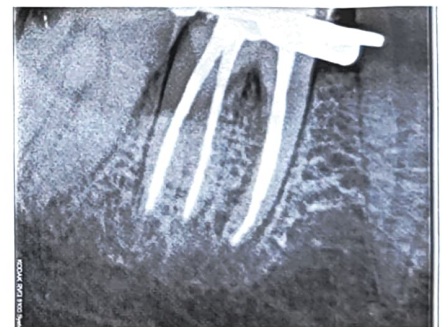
CASE I: Oburation Radiograph
